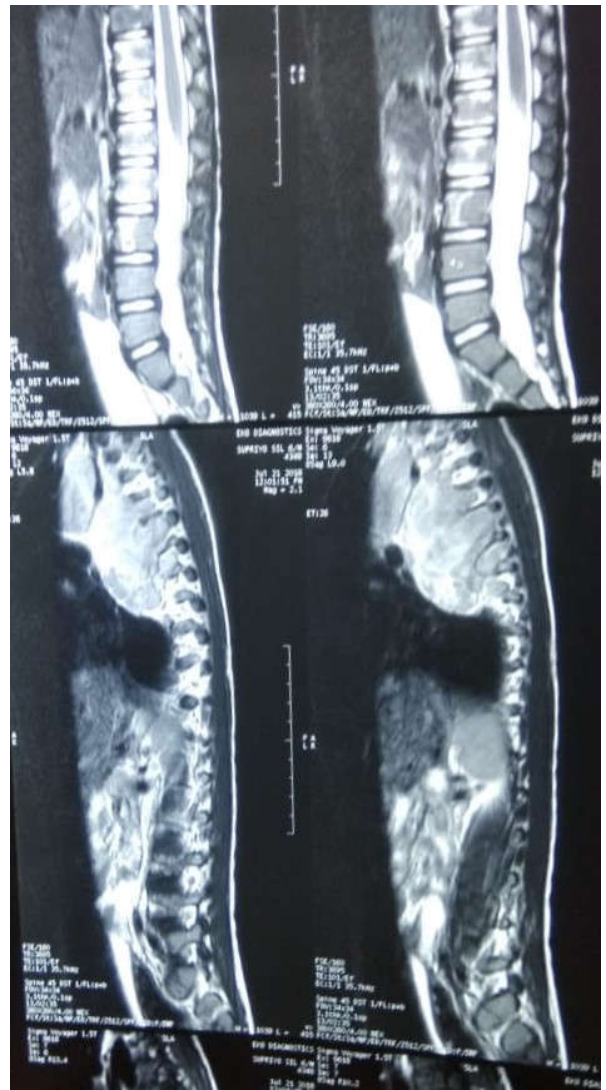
Magnetic resonance image of thoracolumbar spine shows posterior mediastinal mass encroaching spinal canal.
